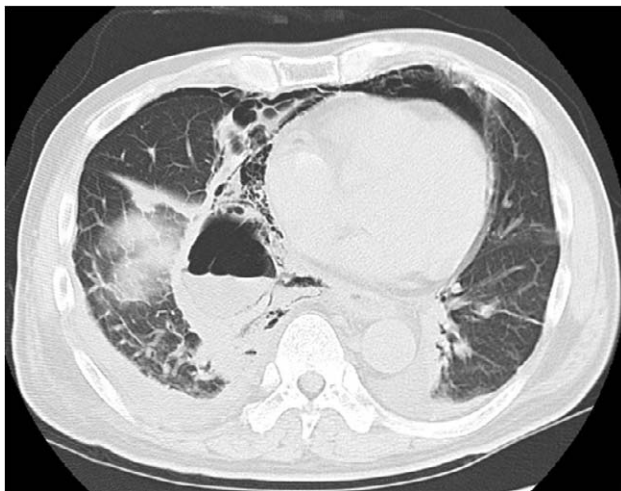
CT scan showing a mediastinal abscess associated with pneumomediastinum and subcutaneous emphysema.
